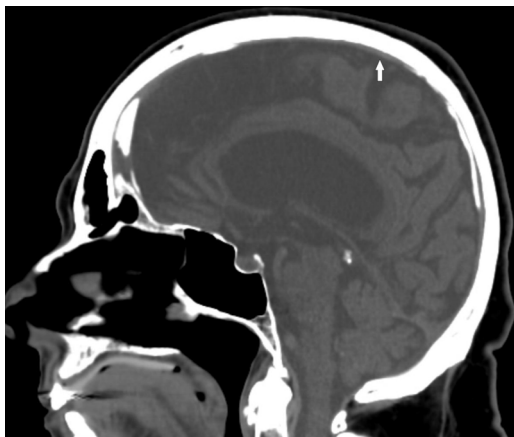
Unenhanced CT head demonstrates small caliber of the superior sagittal sinus (arrow).
